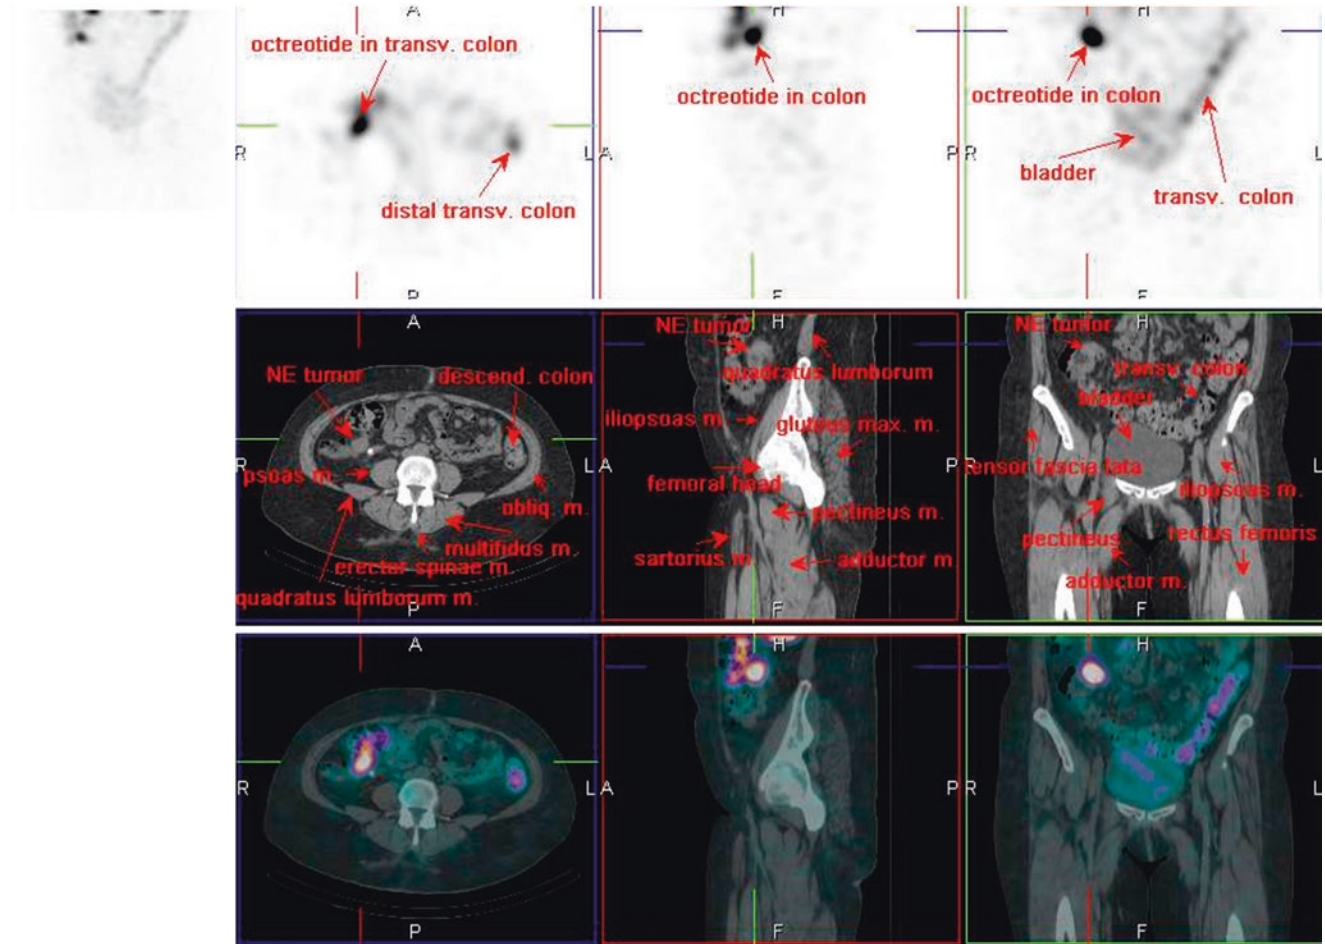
¹¹¹In-octreotide SPECT/CT
